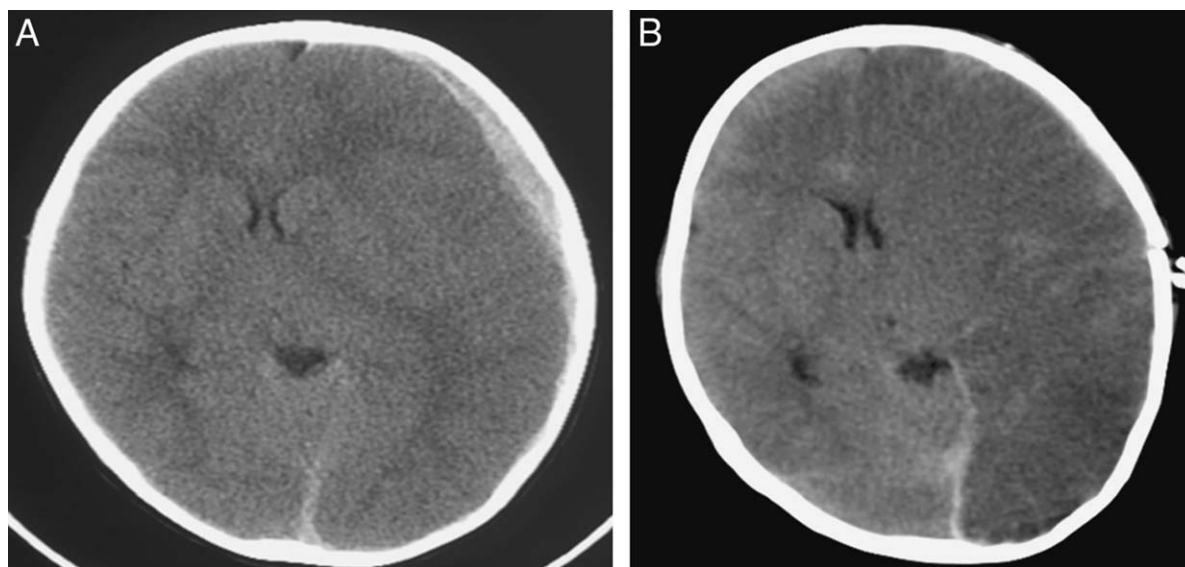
Two-year-old boy with a fall from a bunk bed resulting in acute left subdural hematoma. (A) Acute CT scan, with midline shift. Hemispheres appear to have similar density at this time-point. The patient underwent emergency clot evacuation. (B) Four days post-injury. The child has developed hypodensity and swelling of the entire left hemisphere. He underwent aggressive management of intracranial pressure and survived with a right hemiparesis and hemianopsia.
